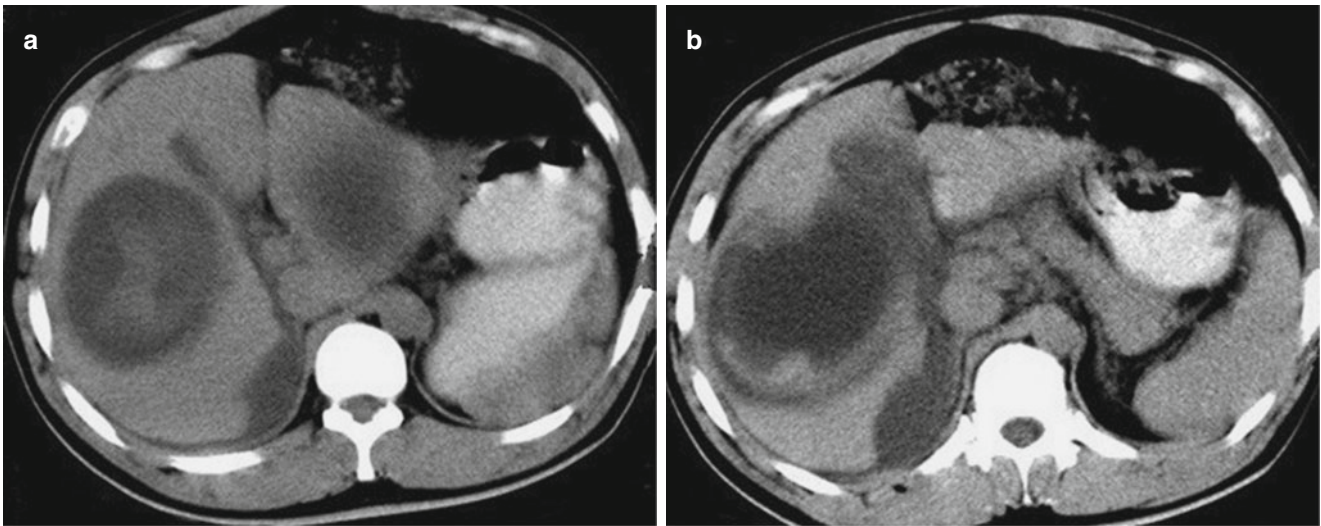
Hepatic hydatid rupture. (a, b) Plain CT scanning demonstrates cyst rupture in the right liver lobe. The lesion has poorly defined boundary. In the cystic lumen, the density is increased. In the gallbladder fossa and around the liver, effusion is observable
